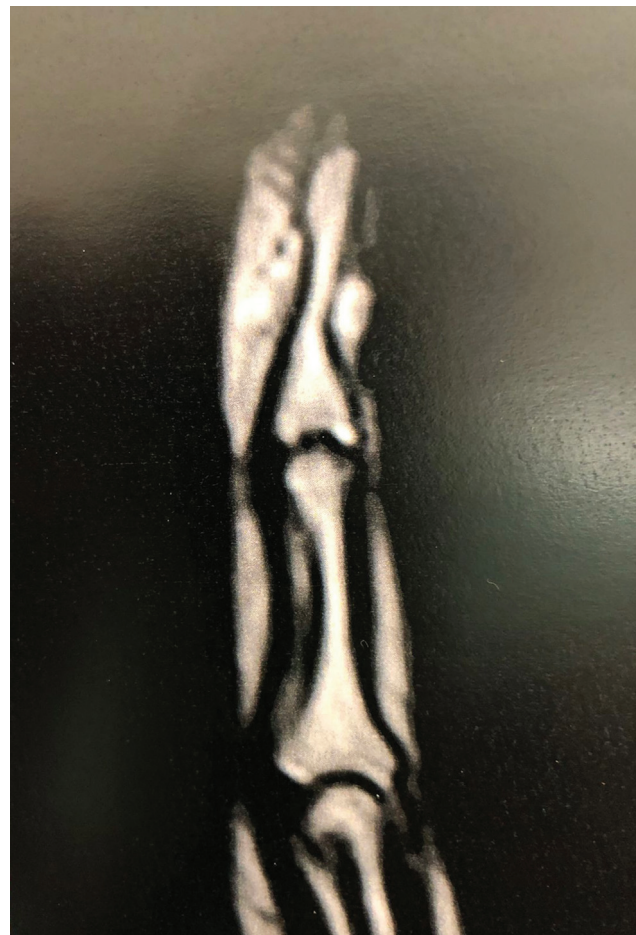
Magnetic resonance imaging scan of a finger showing a subungual glomus tumor.
